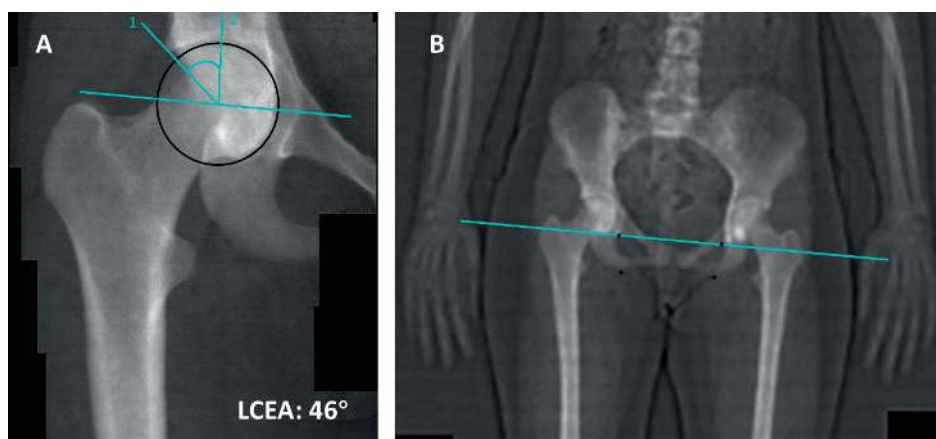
Measurement of lateral center edge angle (LCEA) on a dual-energy x-ray absorptiometry (DXA) image of the right hip. (A). The LCEA of 46° in this sample is formed by the intersection of two lines. The first line originates from the center of the femoral head and extends to the most lateral bony edge of the acetabulum. The second line is generated perpendicular to the horizontal pelvic reference line, as determined on the full-body DXA image. (B). Full-body DXA image depicts the horizontal pelvic reference line. This horizontal reference line was established to correct for pelvic obliquity and was determined based on the average of 2 lines between the most superior points of the obturator foramen and the most inferior points of the ischial tuberosity on both hips.
